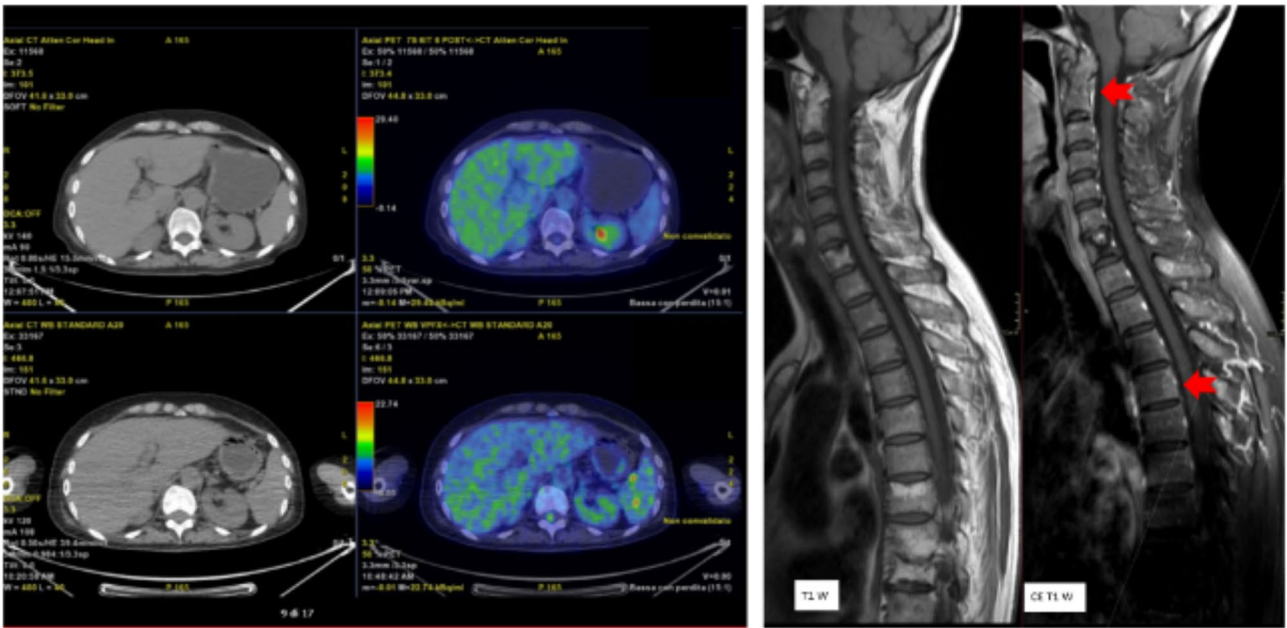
MRI and PET scan showing favorable disease response
